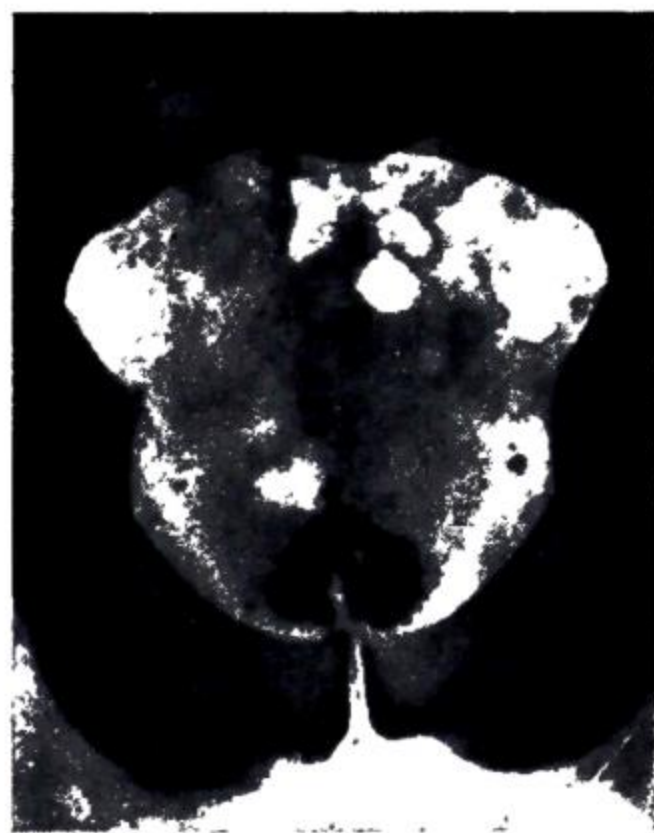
Radiograph showing endogenous prostatic calculi.
